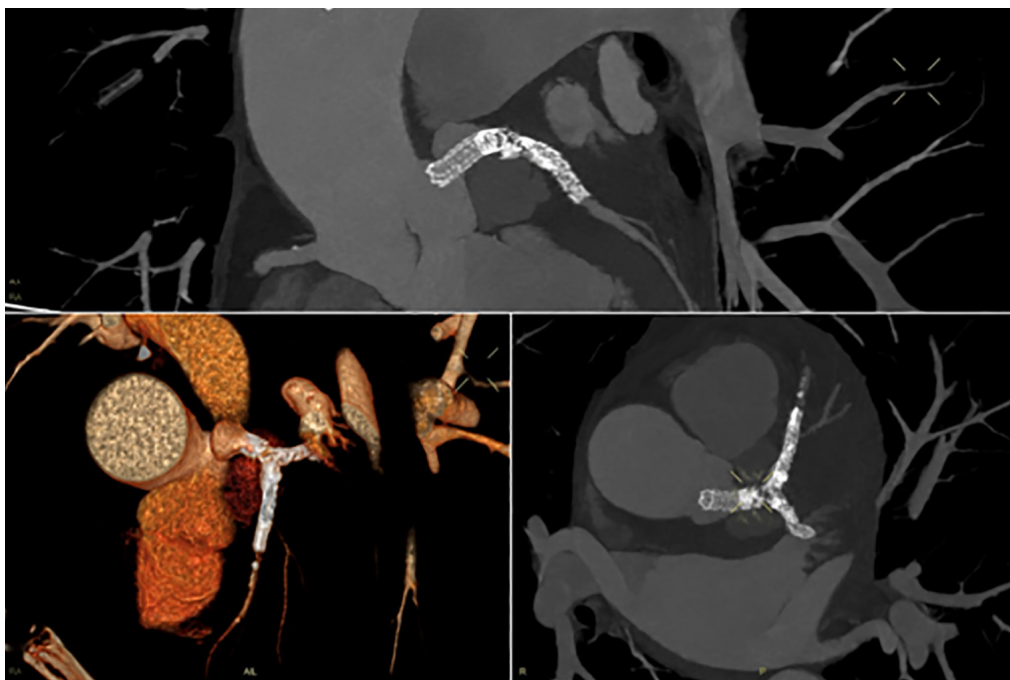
Coronary computed tomography angiography confirming a partially thrombosed pseudoaneurysm extending into the proximal segments of the left anterior descending and circumflex arteries.
